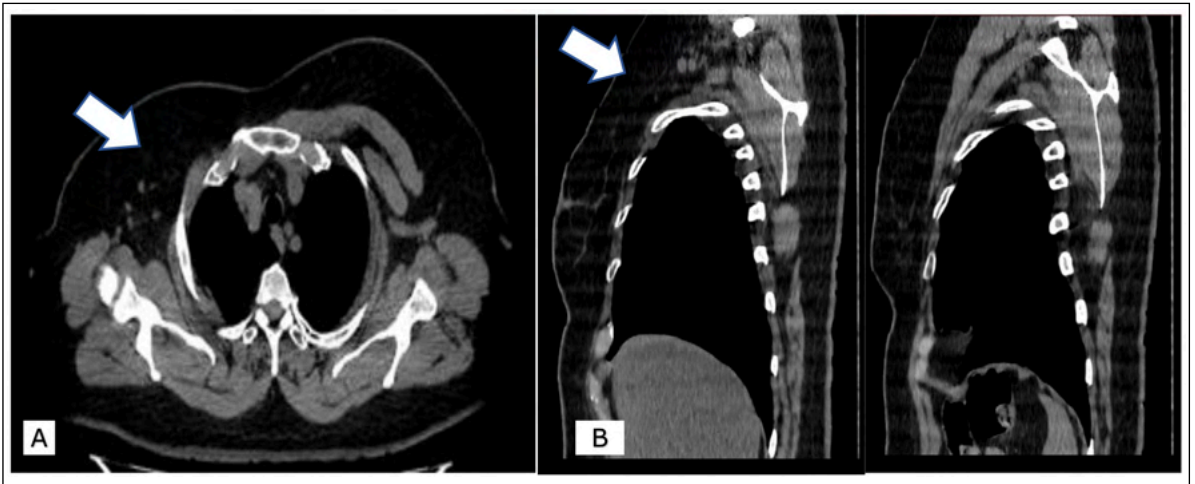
A: Computed tomography of the chest in the soft tissue window, in axial section, showing the absence of the pectoralis major and pectoralis minor muscles (arrow). B: Computed tomography of the chest in sagittal view confirming the absence of the pectoralis major and minor muscles on the right (arrow) compared to the left side, where the presence of these muscles is noted.
